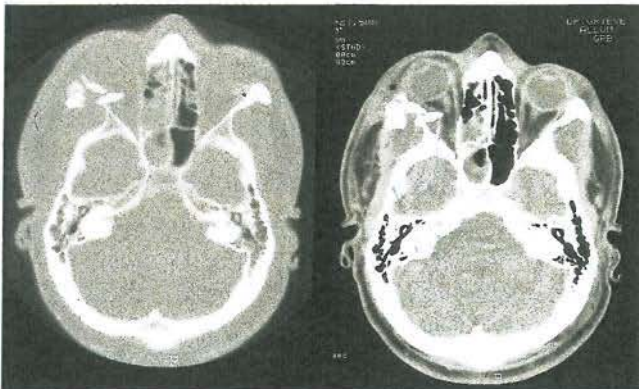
Axial CT scan showing a right lateral wall fracture with bony fragments impinging on the optic nerve
